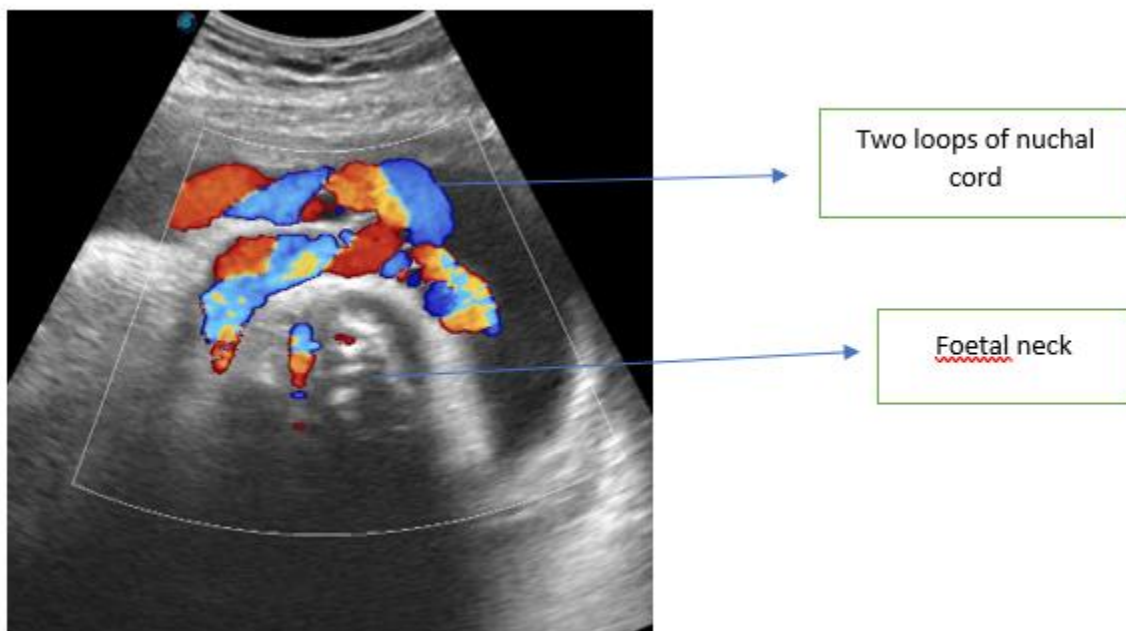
Prenatal sonographic image of nuchal cord, demonstrated with colour Doppler.
